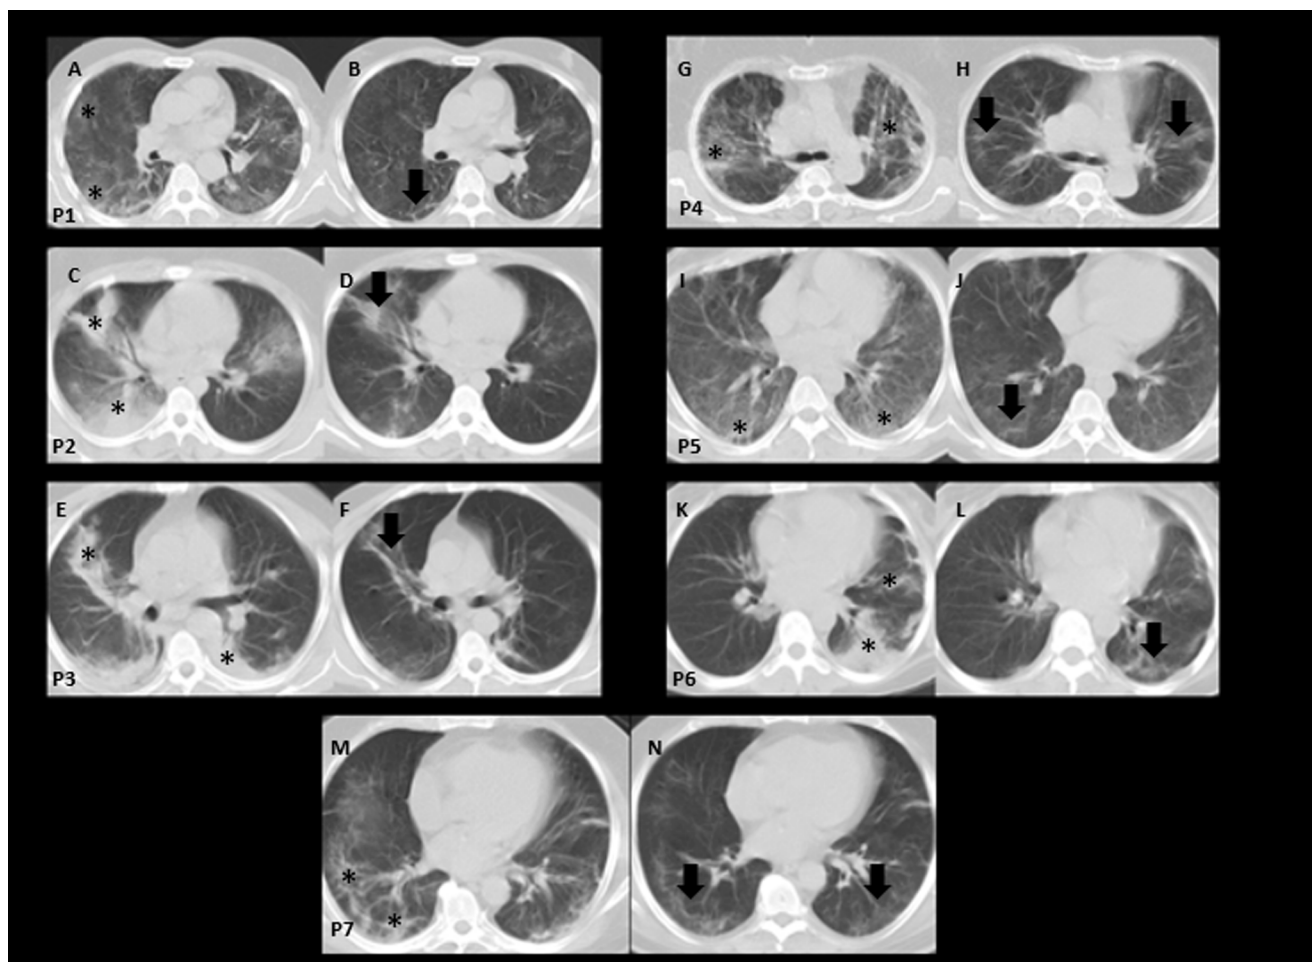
Chest CT images of seven patients (P1- P7) who had radiologically improved lung after receiving cyclosporine at the time of admission. Non-contrast enhanced CT images of patient 1 (P1- A) showed bilateral patchy consolidations in both *peri*-bronchovascular and subpleural distribution (*) that improved considerably (arrow) after receiving cyclosporine (P1- B). Patient 2 had segmental *peri*-bronchovascular and subpleural consolidations (*), more confluent than patient 1 (P2- C) which improved significantly (arrow) after medical therapy (P2-D). Patient 3 had bibasilar infiltrations as well as subsegmental patchy consolidation with irregular border within right middle lobe (*) (P3-E). Repeated CT images (P3-F) after cyclosporine administration show substantial decrease lung infiltrations (arrow). Patients 4, 5, 6 and 7 CT images also showed similar Covid-19 imaging manifestations with considerable decreased in the severity of lung infiltration before (*) and after (arrow) cyclosporine therapy (P4, P5, P6 and p7).
